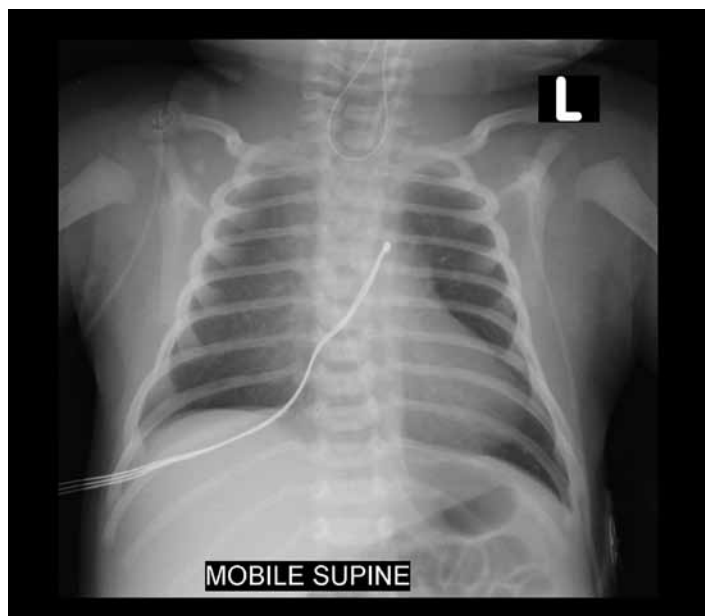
Chest Xray showing nasogastric tube curled in the upper oesophageal pouch in a child with oesophageal atresia
